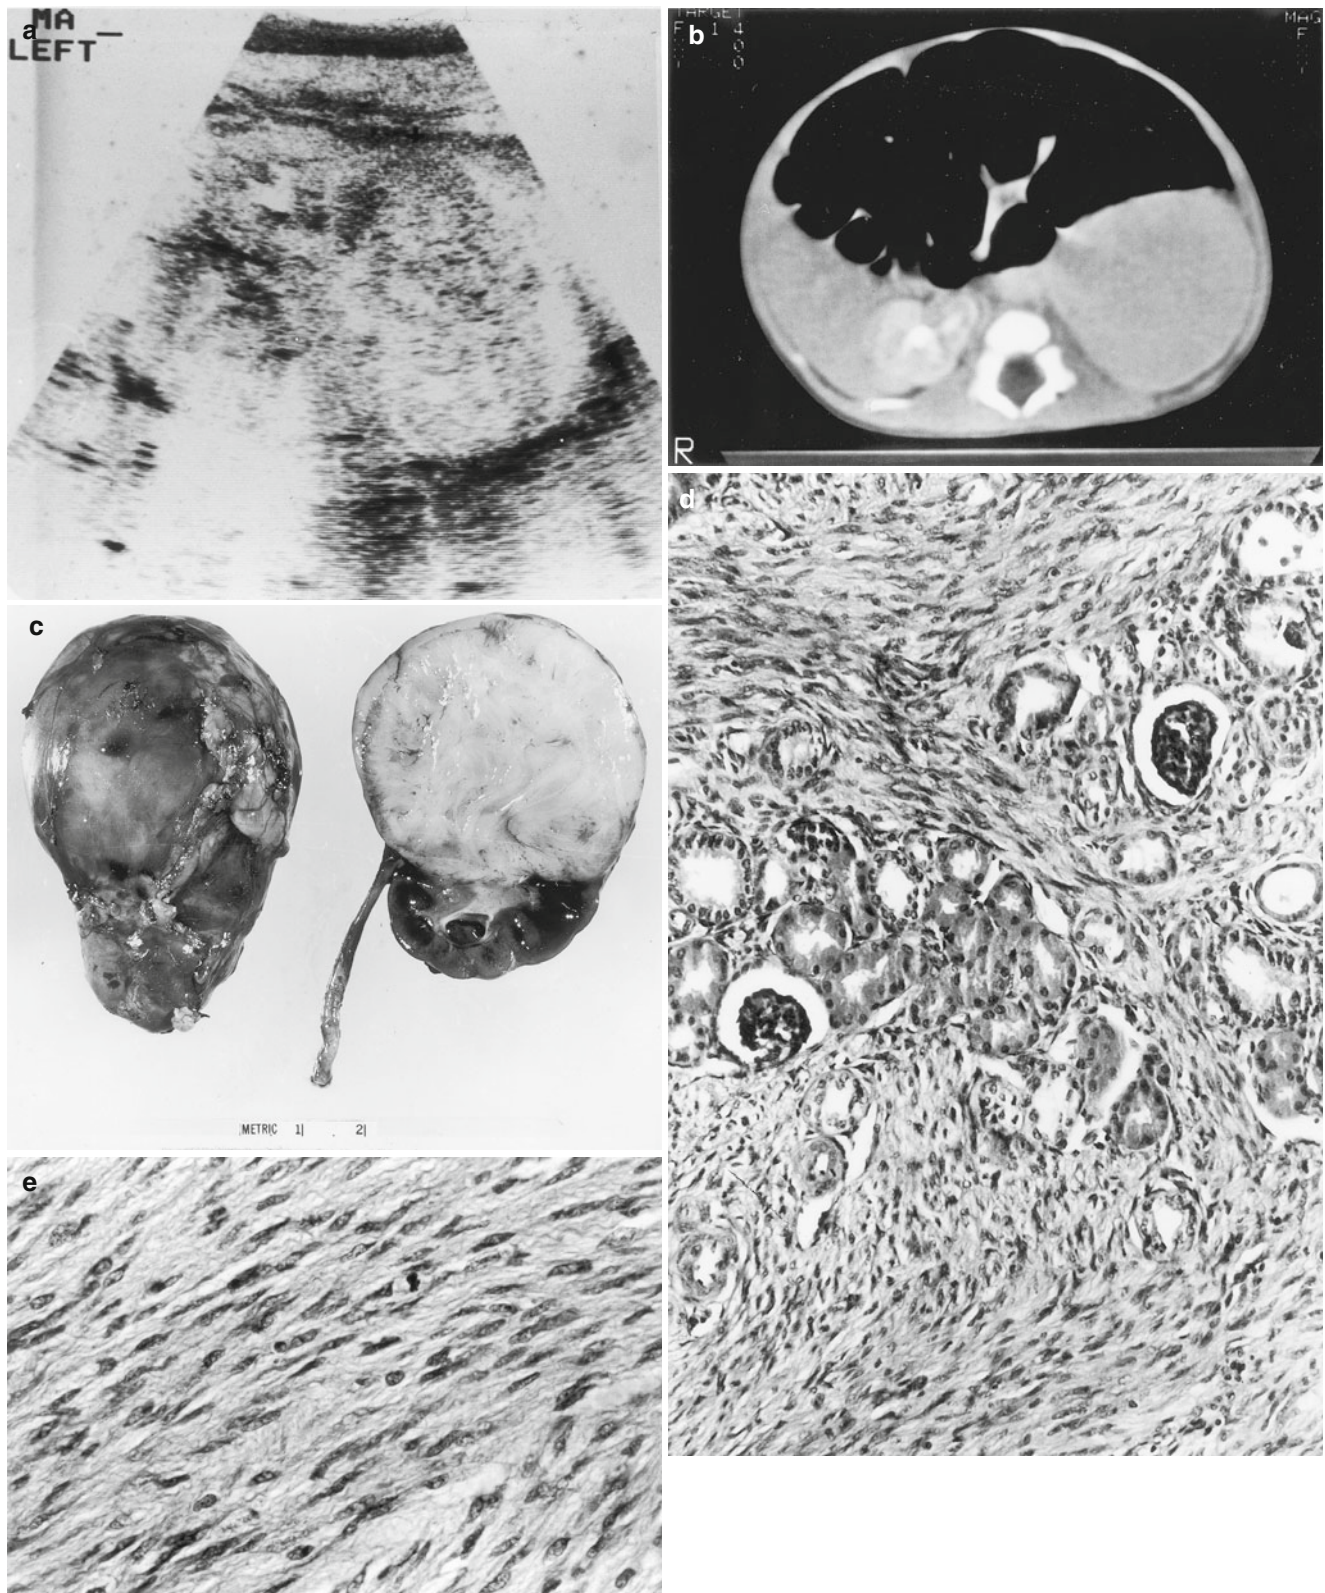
Congenital mesoblastic nephroma, classic. (a) Sonogram of a 5-day-old male with a left flank mass noted at birth demonstrating the lesion. (b) CT scan confirms the sonographic findings. (c) The tumor, 50 g and 5×5 cm, has a whorled appearance similar to a uterine
